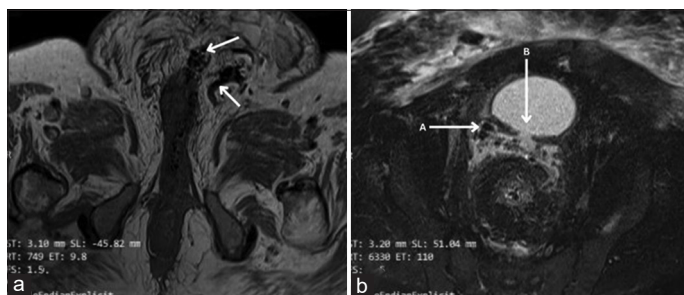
(a) Air pockets in ischiocavernosus muscle, within bulbospongiosus in the pubic; (b) An enormous collection with air pockets noted posterior to urinary bladder. A focal bladder defect was noted in the posterior wall communicating within the collection. Image shows axial oblique T2- magnetic resonance imaging of the male pelvis with A and B specifically indicating: (a) Large collection with air pockets noted posterior to urinary bladder. (b) Focal bladder defect in the posterior wall communicating within the collection
